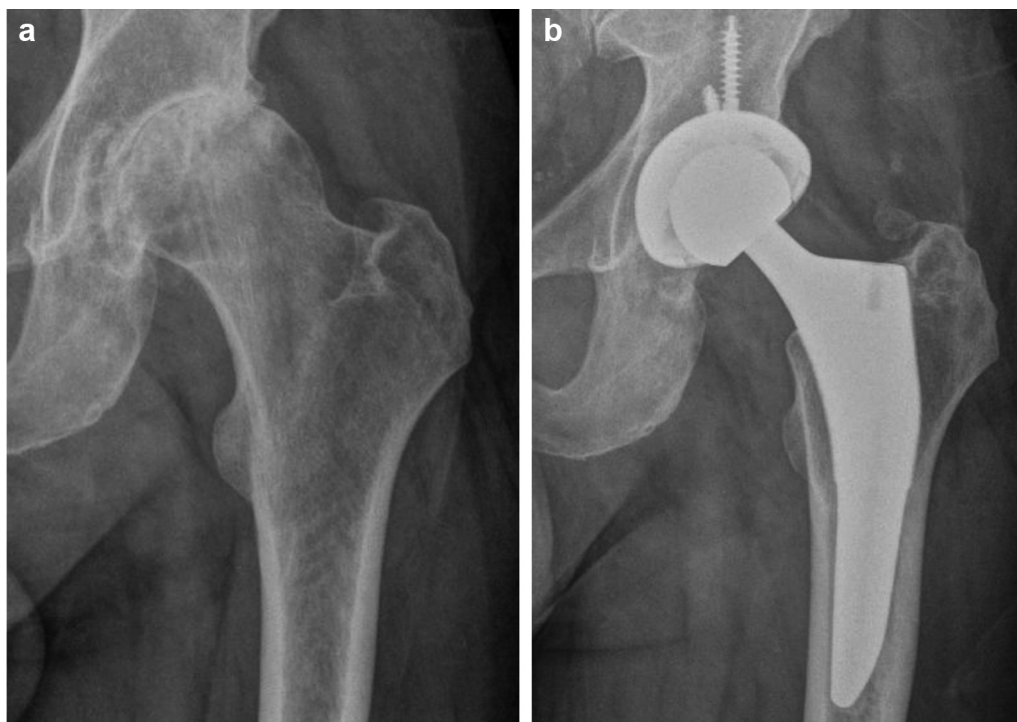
Sixty-six-year-old male with 18 months of left knee pain. Hip radiographs (a) revealed Grade 3 OA. Knee pain completely resolved after left THA (b).
